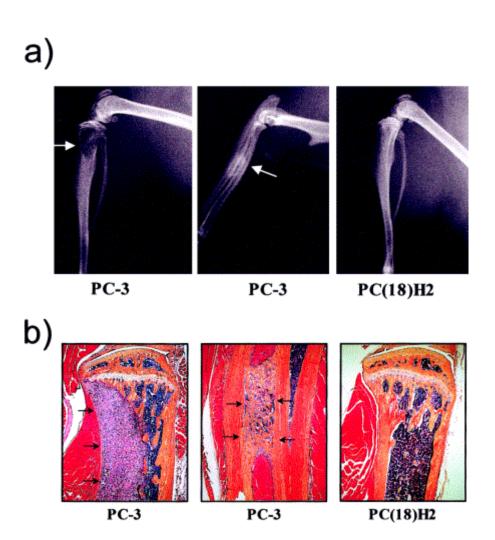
(A) Radiographic appearance of representative bone metastases caused by parental PC-3 cells or PC-3 hybrids containing an intact copy of chromosome 18. Panel 1 shows a characteristic osteolytic lesion in the proximal
